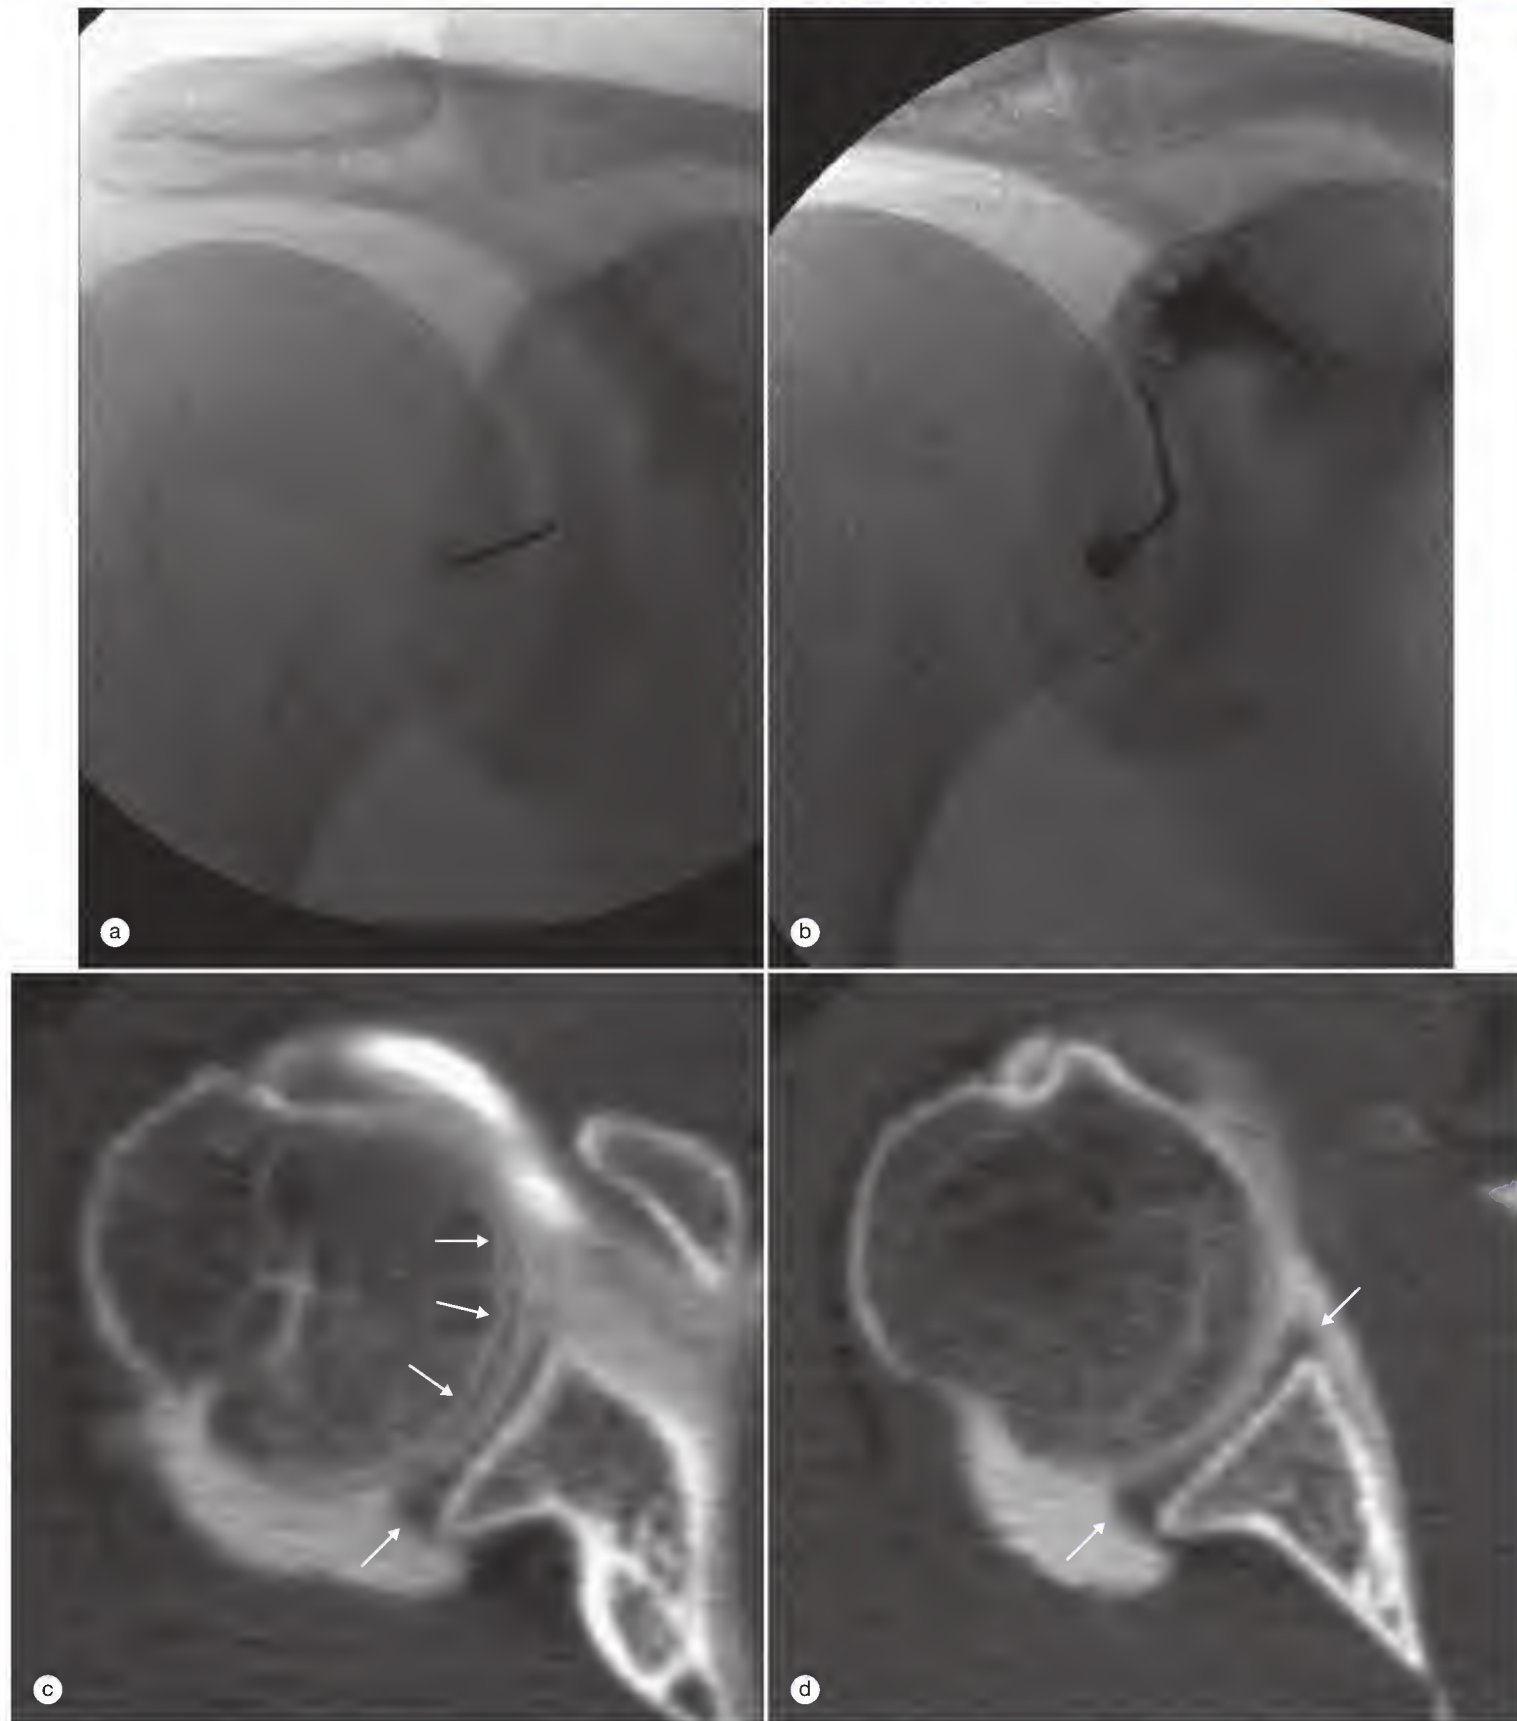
Computed tomographic (CT) arthrography of the shoulder. (a) Anteroposterior fluoroscopic image of the right shoulder shows needle placement in the mid-distal third of the glenohumeral joint. (b) Contrast material subsequently injected into the glenohumeral joint is seen flowing along the curvilinear contour. (c) Axial multidetector CT scan acquired through the right shoulder joint after intraarticular injection of dilute radiographic contrast agent demonstrates the articular cartilage of the humeral head as a low-density structure (triple arrows) clearly outlined by the high-contrast material. The posterior labrum is well visualized (single arrow). (d) A more distal slice demonstrates the anterior and posterior portion of the glenoid labrum (arrows).
